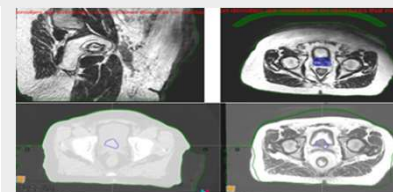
Incorrect external contour due to MR motion artefact (Top), external contour difference between CT sim with VC and MR sim without VC (Bottom).
